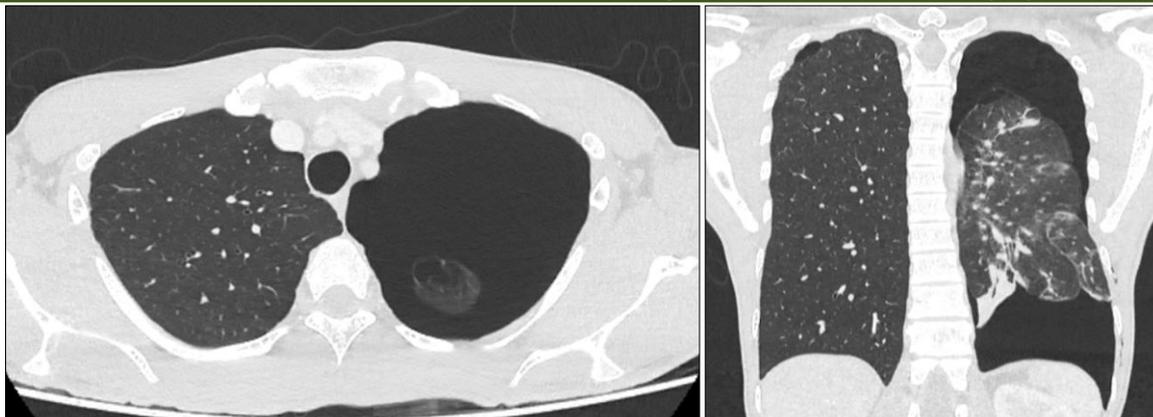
High-resolution computed tomography (CT) scan images of the thorax in axial and coronal planes. These images clearly demonstrate the presence of apical subpleural blebs in the right upper lobe, consistent with the etiology of the patient's spontaneous pneumothorax. The CT axial cut (left) localizes multiple small air-filled blebs adjacent to the pleural surface, while the coronal reconstruction (right) highlights the distribution and extent of these lesions along the upper lobe periphery
